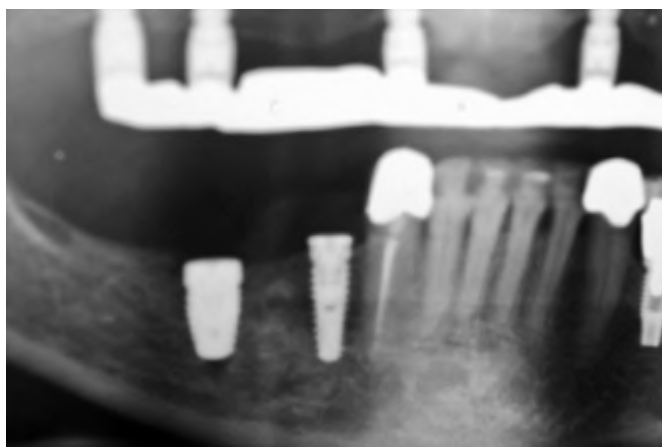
Panoramic radiograph that was made immediately after the implants were placed. Even though a 5-mm-diameter implant was originally called for in the molar area, a 6-mm-diameter implant was placed because it obtained primary stability, whereas the 5-mm-diameter implant did not.
